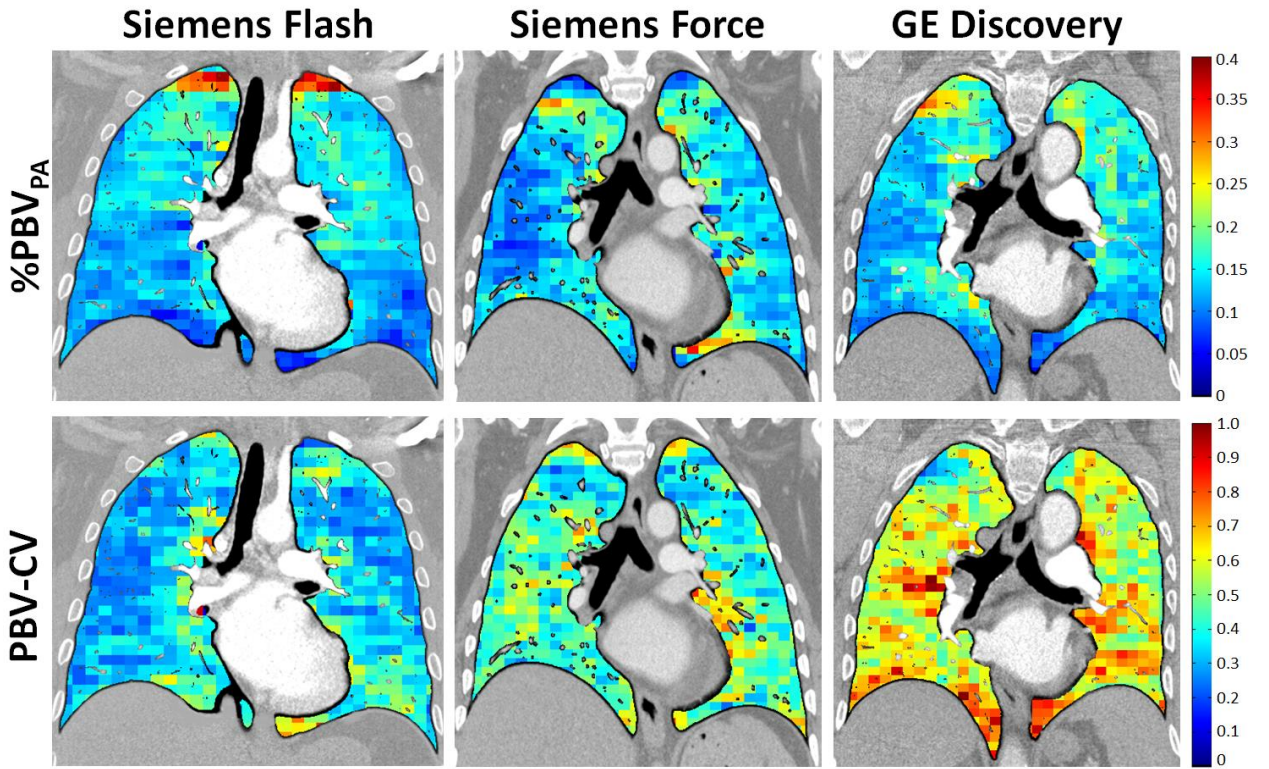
Regional %PBVPA (top) and PBV-CV (bottom) overlaid on mixed CT image in (left) Siemens SOMATOM Definition Flash, (middle) Siemens SOMATOM Force and (right) GE Discovery 750 HD.
